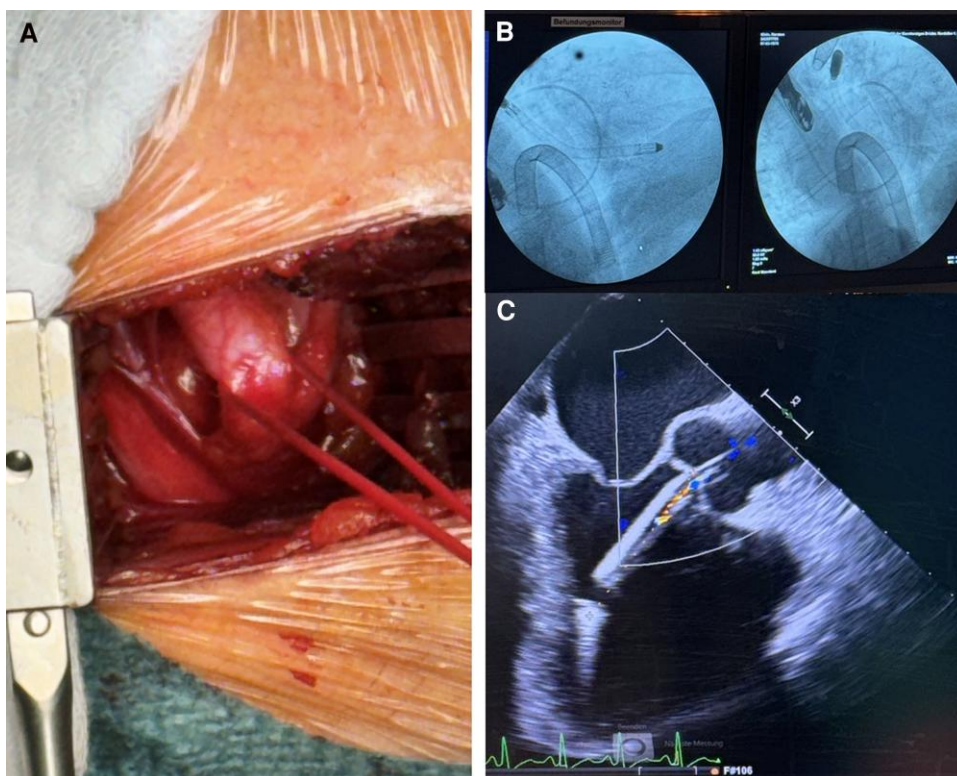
Surgical trans-axillary insertion of the Impella 5.5 device. Surgical trans-axillary Impella insertion by surgical cutdown (A) and fluoroscopy (B) and/or echocardiographic (C) guidance.
